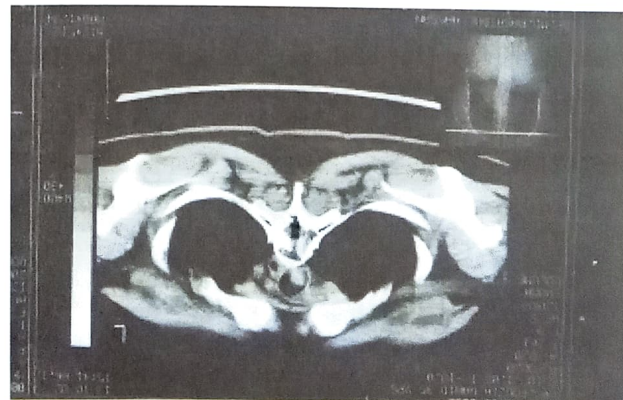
HRCT scan of chest
